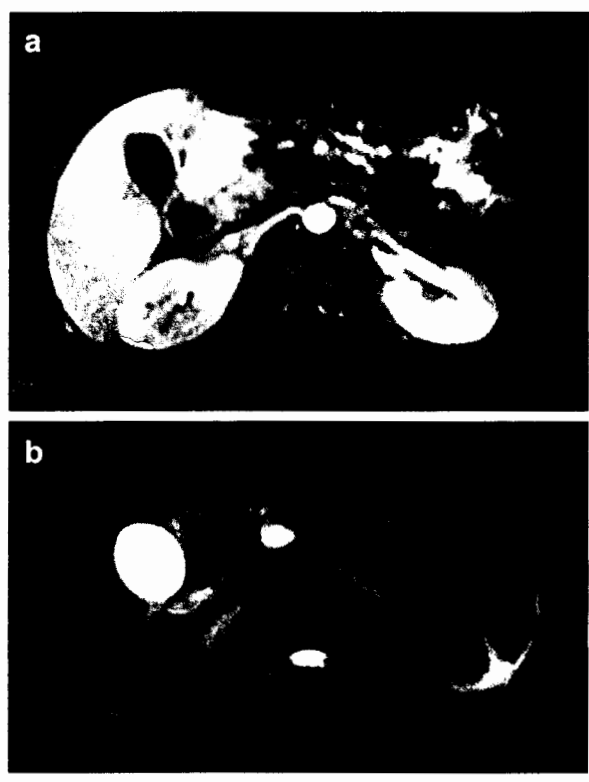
A 25-year-old man with upper abdominal trauma following a motorcycle crash. Fat-suppressed T1-weighted axial MR image (a) shows the site of pancreatic laceration and a fluid collection. An MRCP (not shown) revealed ductal integrity. The follow-up study after 20 days (b) shows a residual pseudocyst at the level of injury
